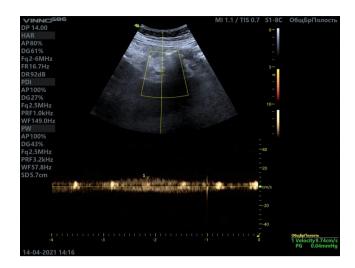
In the mode of spectral dopplerography, hepatopetal monophasic laminar blood flow with reduced velocity indicators of 9.7 cm/s is determined
